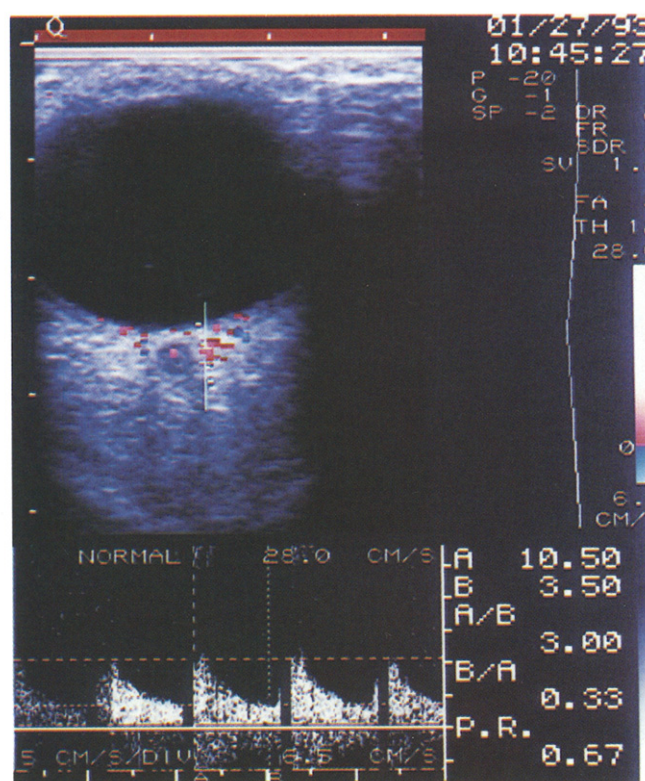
Color Doppler image and waveform of the temporal short posterior ciliary artery of a 64-year-old subject. Red pixels = flow toward the probe; blue pixels = flow away from the probe. The cursor is positioned over the vessel which is adjacent to the optic nerve shadow. A = peak systolic velocity in cm/sec; B = end-diastolic velocity. P.R. = Pourcelot's ratio.
